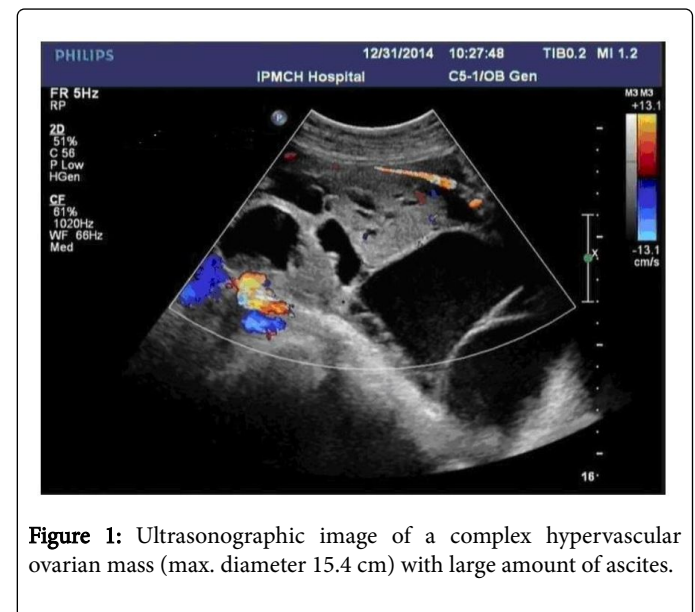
Ultrasonographic image of a complex hypervascular ovarian mass (max. diameter 15.4 cm) with large amount of ascites.
